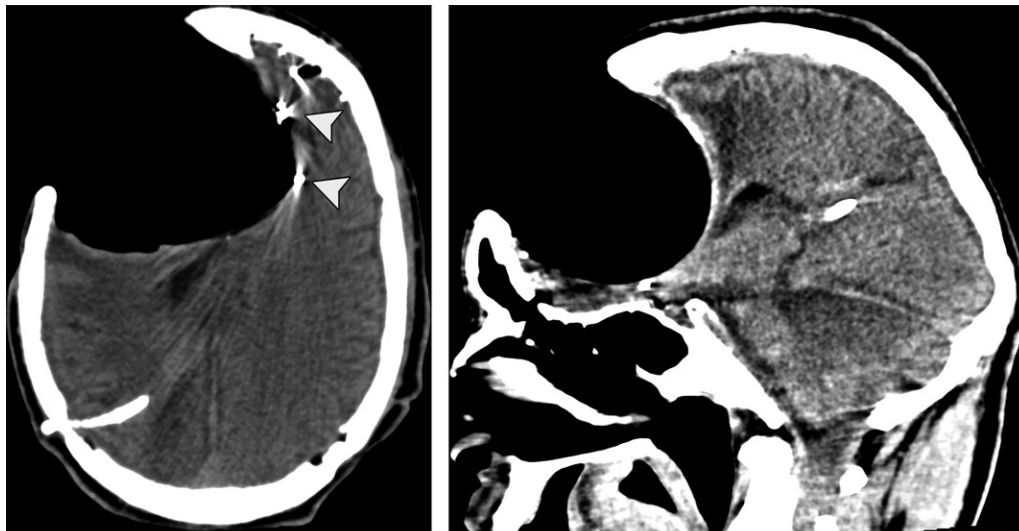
Paradoxical hernia in a 32-year-old man who was shot in the head three times. He underwent decompressive craniectomy and developed sinking flap syndrome. (a) Axial nonenhanced CT image shows left midline displacement and right ventricle compression with associated edema. There is metal artifact in the left frontal lobe from remnants of the bullet (arrowheads). (b) Sagittal CT image demonstrates the frontal and temporal lobe displacement.
